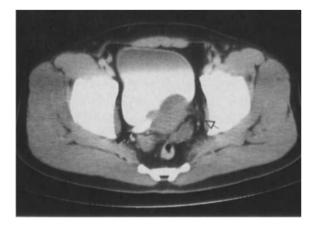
Primary lymphoma of the urinary bladder on CT. A lobulated mass involves the posterolateral aspect of the bladder; both ureters are dilated (*closed arrow on right, open arrow on left*). (BINKOVITZ et al. 1988)
